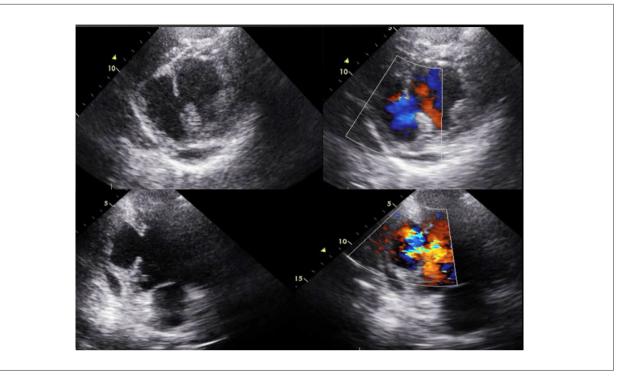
Echocardiogram with evidence of aneurysm in the lower wall with flow inside with color Doppler. Akinesia in the lower wall.
